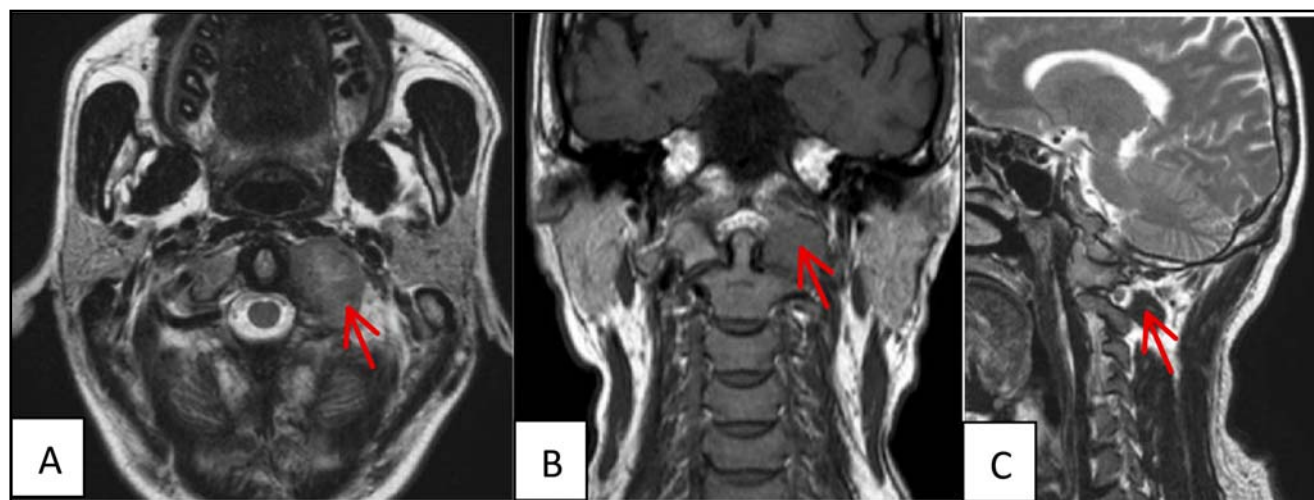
MRI showing the abnormal shadow signal in the left lateral mass of the atlas of the patient, indicating spinal metastasis. (A). Aerial view; (B). Rear view; (C). Side view.
